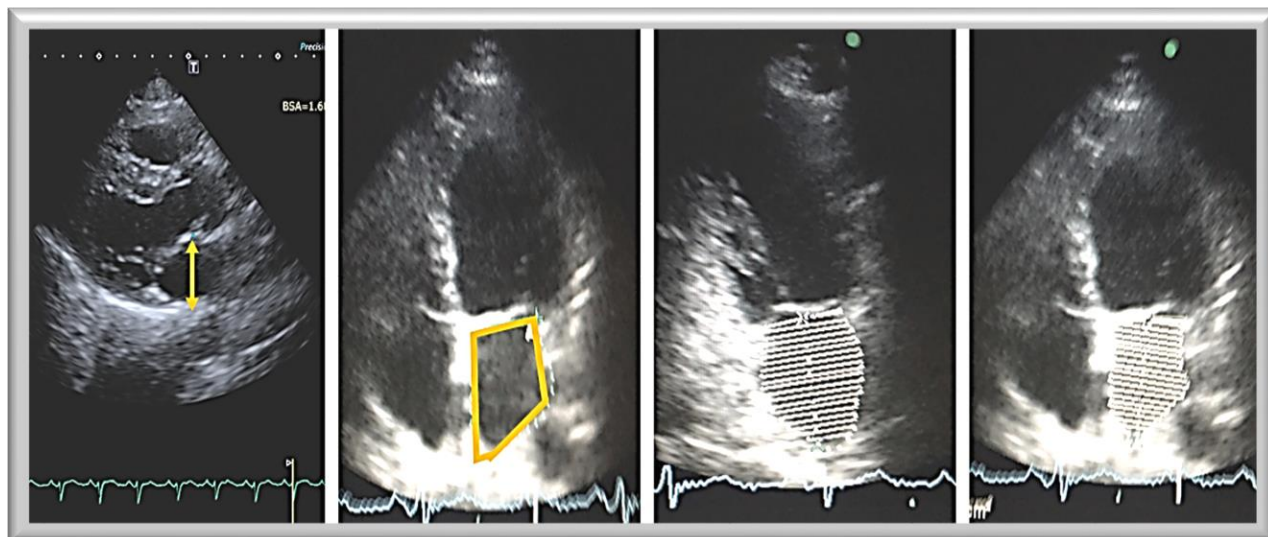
Echo derived left atrial parameters of prognostic importance: A-diameter, B-area, C and D-volume in apical 4 chamber view.
